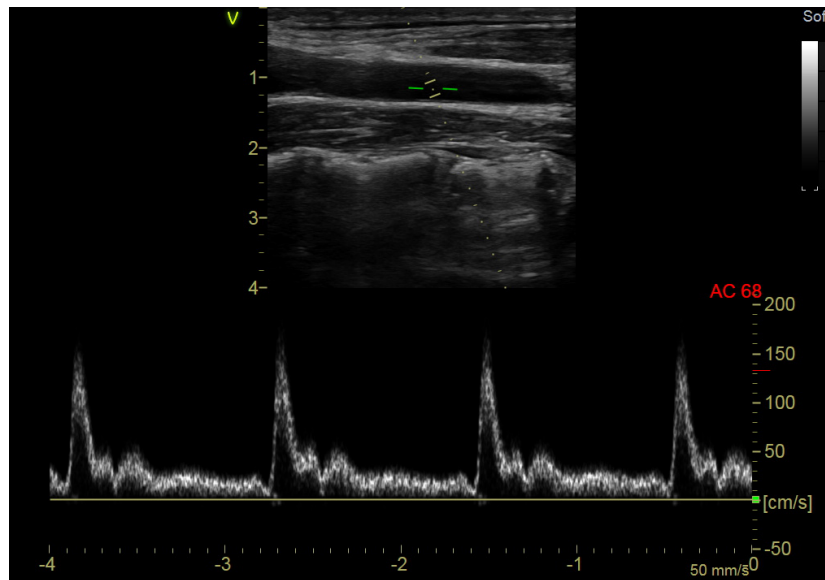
Doppler image showing the blood velocity inside the carotid artery
